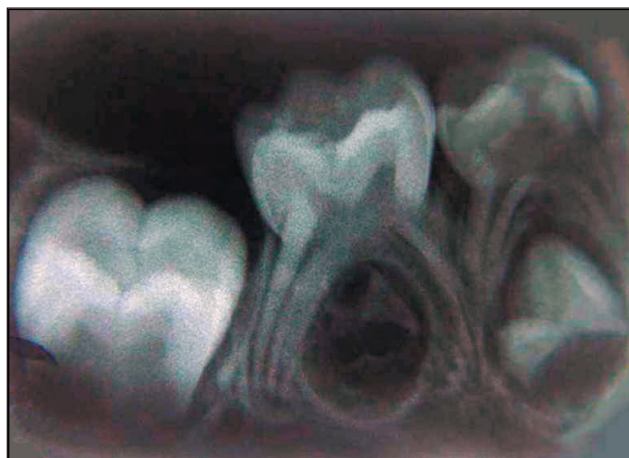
Radiograph showing the presence of the permanent tooth germs.
